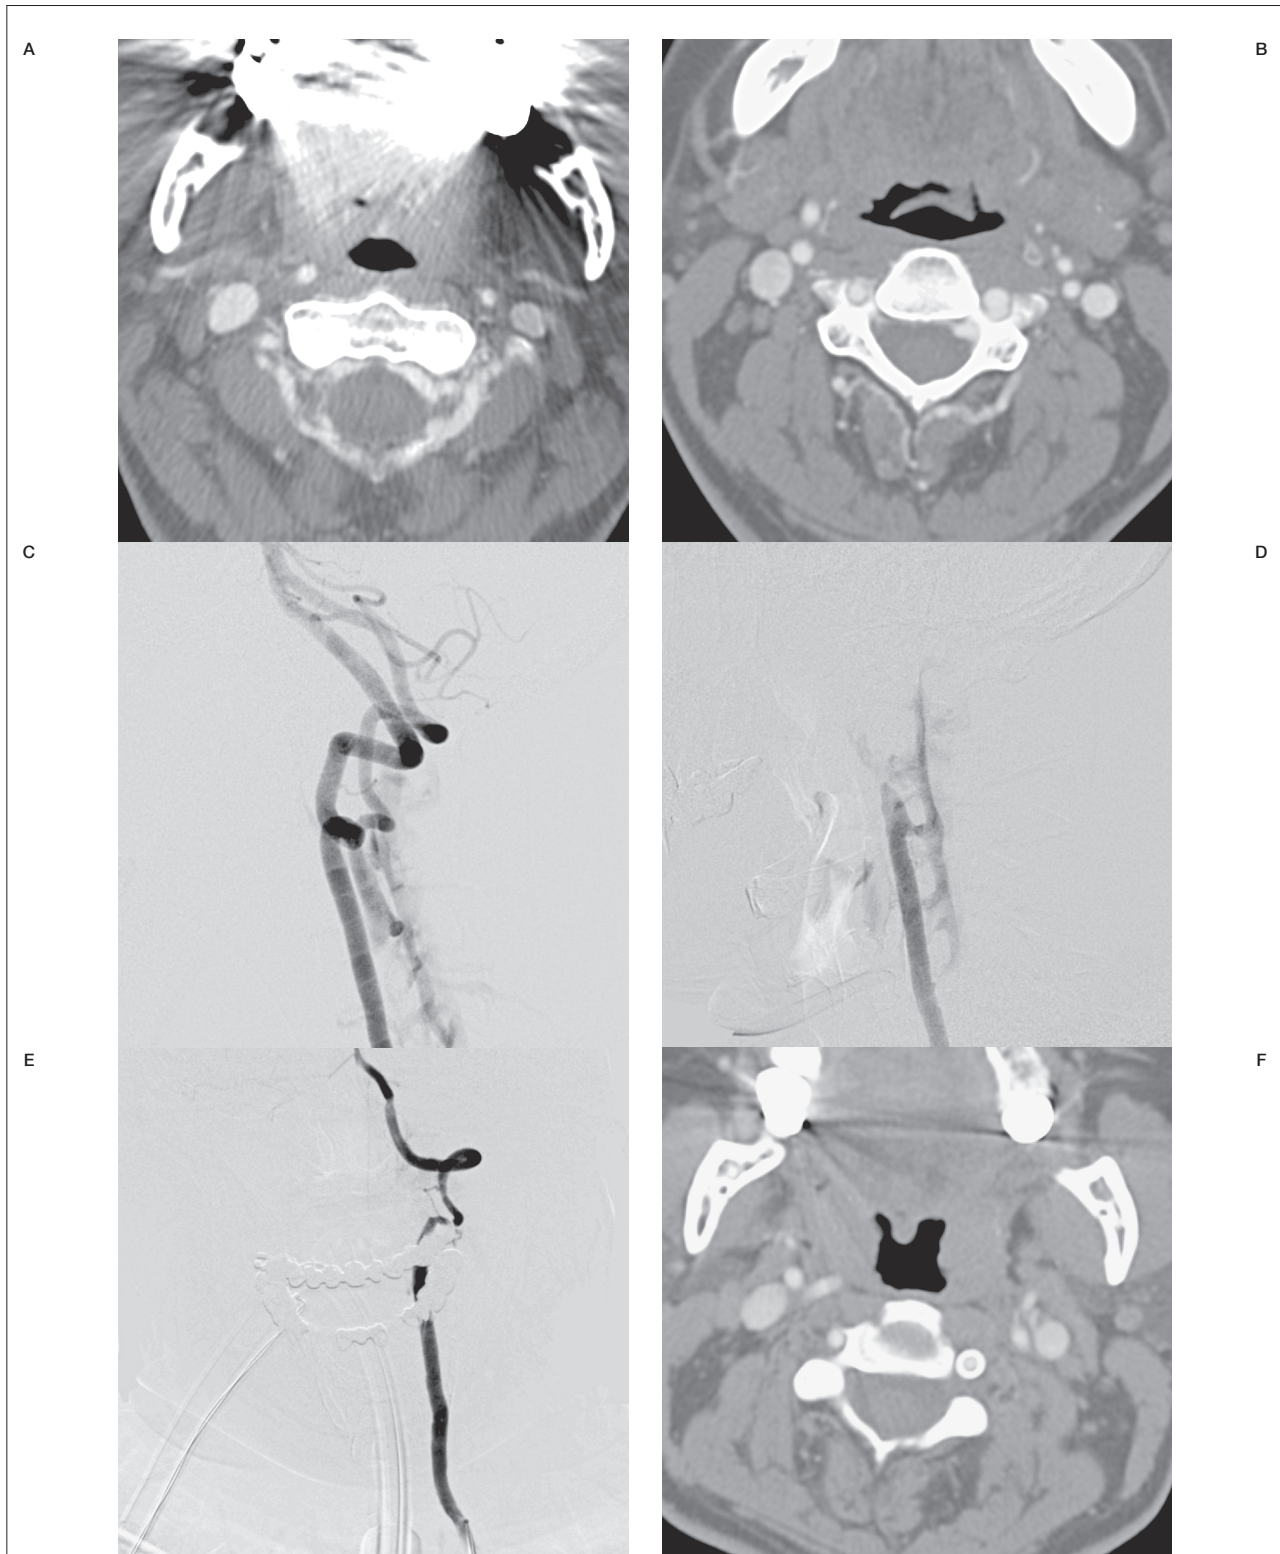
A 43-year-old woman with a history of blunt neck injury had pulsatile tinnitus and neck soreness. A) CT angiography (CTA) showed prominent epidural and paraspinal engorged venous structures in upper neck. B) Suspected direct connection between the left VA and adjacent vein at the C3 level. C,D) Digital subtraction angiography (DSA) of the right and left VA in lateral projection confirmed the left high-flow VV-AVF at the left C3 level. E) After deployment of a covered stent at the C2-5 level and post-stenting angioplasty, the fistula was completely obliterated. F) CTA follow-up 8 months after treatment showed lumen patency of the stent without recurrent fistula.
